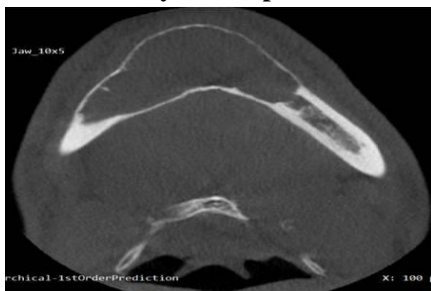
CBCT Axial view showing cortical expansion with intact cortical plates
